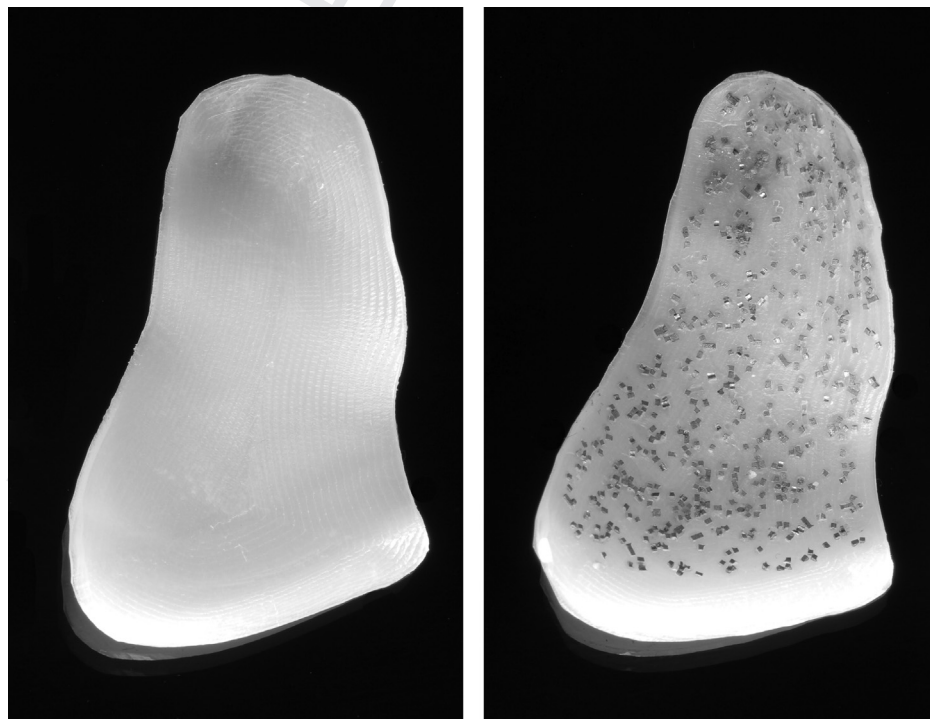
Patient-specific ultrahigh molecular weight orbital implants. On the left: an implant just after computer-aided manufacturing, i.e. computer numerical control milling. On the right: the same implant after ultrasound titanium cube marking.
